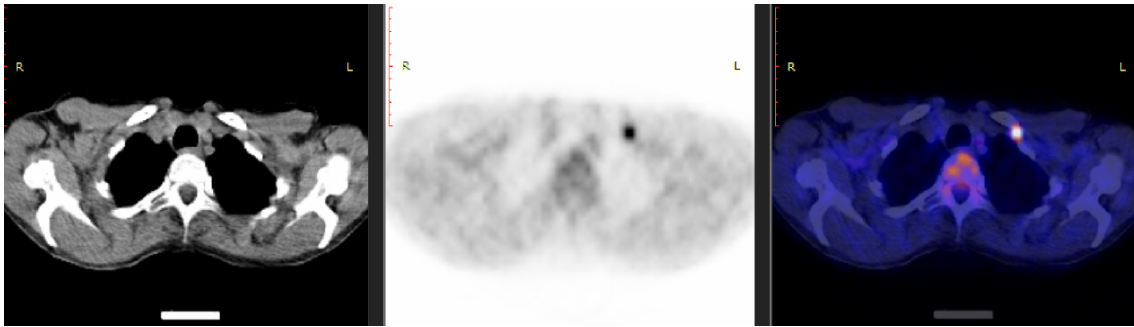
A 58-year-old female patient in the postsurgery status and post-adjuvant chemotherapy due to invasive ductal carcinoma of the left breast. The patient presents for restaging after completion of chemotherapy. Transaxial images show left retroclavicular lymph node 1.5 cm in size, SUVmax = 5.64 consistent with metastatic involvement.
